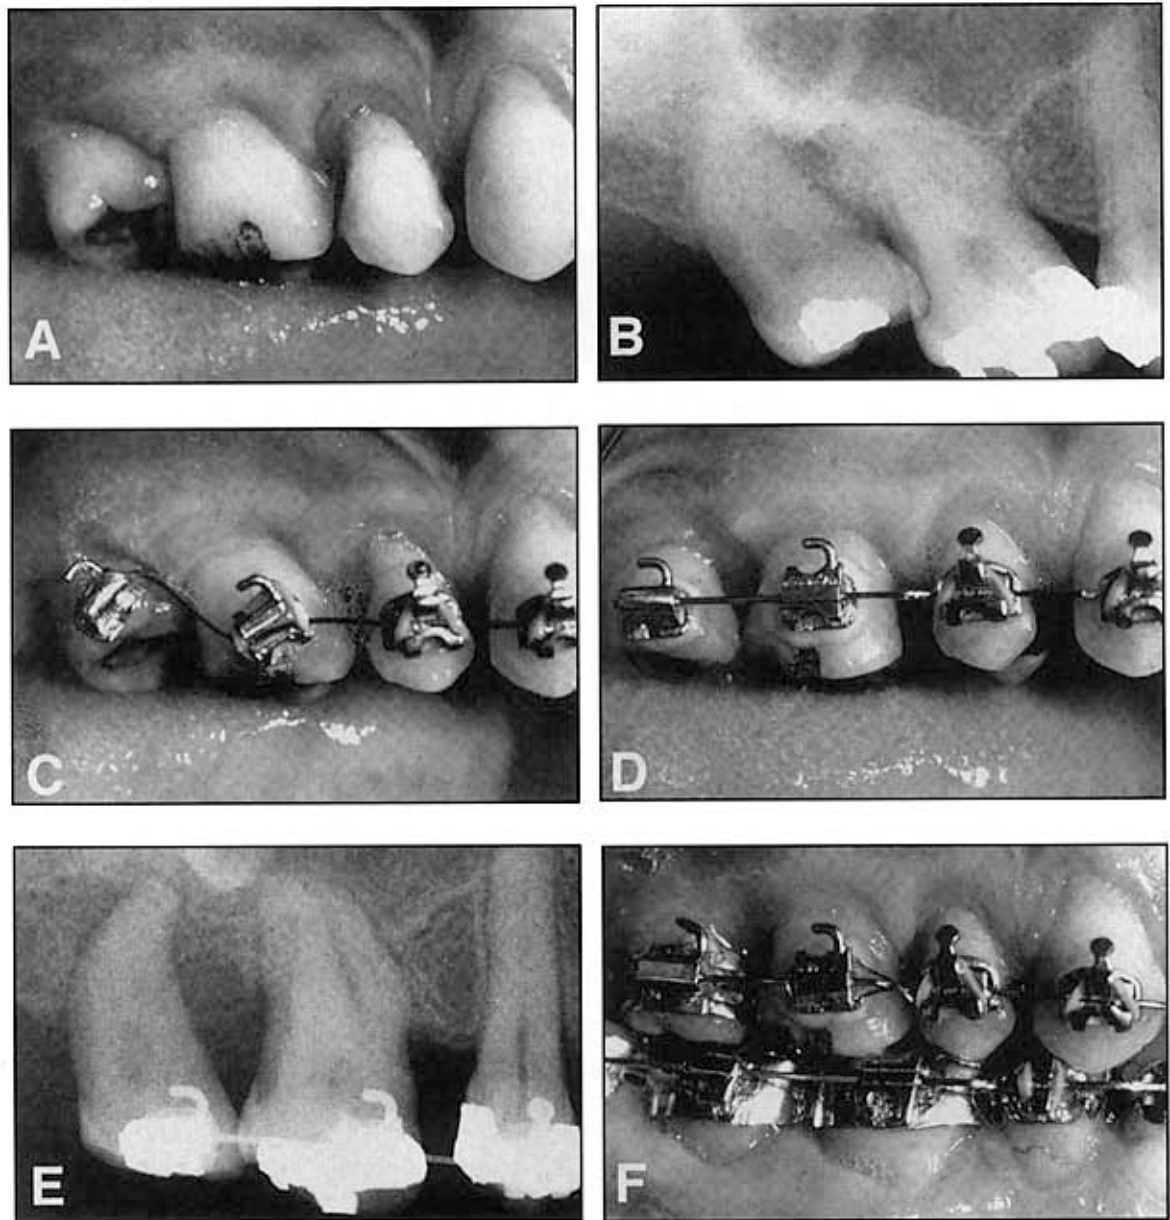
This patient is missing the maxillary right second molar and second premolar (A). As a result, the third molar and first molar have tipped mesially (B). However, the occlusal surface of the first molar is abraded and level with the occlusal plane. Therefore, to upright the tipped teeth, the brackets on the molars must be placed perpendicular to the long axis of the tooth, and not parallel with the abraded occlusal surface (C). As the teeth upright, the marginal ridges and occlusal surfaces are equilibrated (D). The radiograph is used to determine when the posterior teeth are in their correct inclination (E). By placing the brackets in their proper relationship relative to the roots and equilibrating the crowns, the correct occlusal contacts may be established (F).
